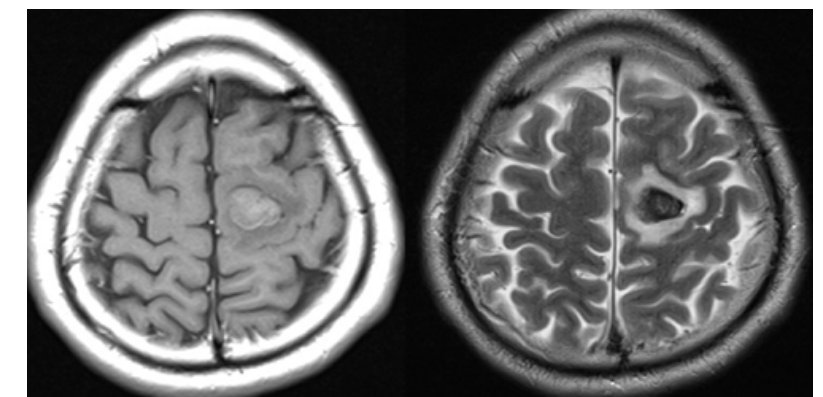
Preoperative T1-MRI, T2-MRI
